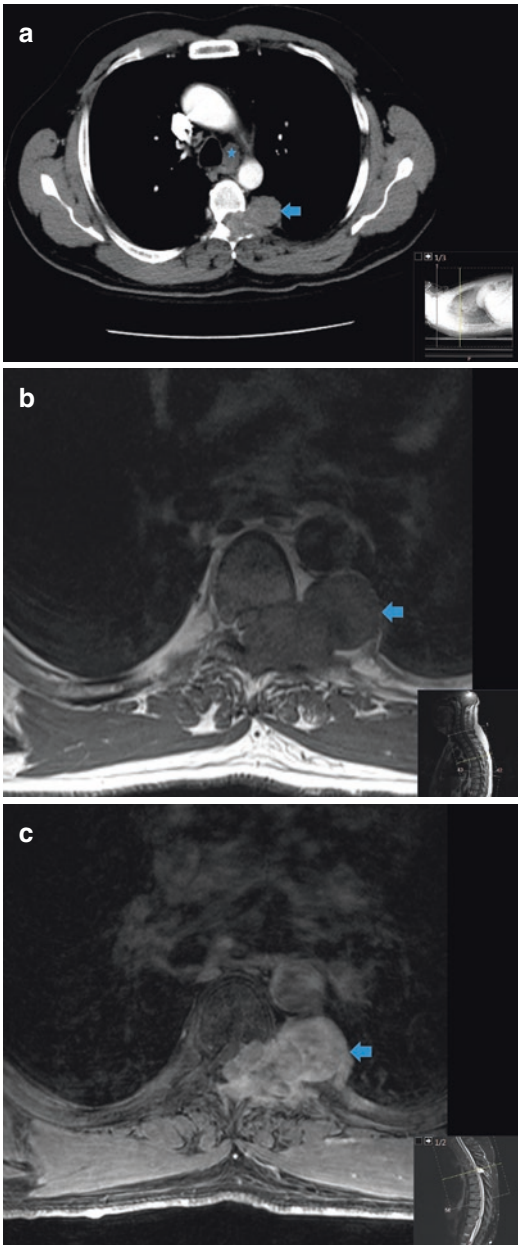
Malignant peripheral nerve sheath tumor. Figure 9.10a is a contrast-enhanced CT of the chest, showing a solid intradural extramedullary mass in the thoracic spine (arrow), eroding the adjacent bony spine, and extending through the left neural foramen into the adjacent pleural space. There is also pathologic mediastinal lymph node (star). Figures 9.10b and c are unenhanced T1 and postcontrast T1-weighted MR images, respectively, showing the solid enhancing mass in the thoracic spine (arrows). The mass was excised, and the pathology was consistent with a malignant peripheral nerve sheath tumor
